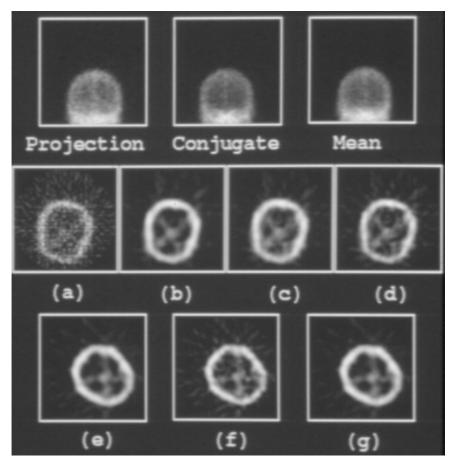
34 show a set of opposing projection images as well as their geometric mean for two patients. Transverse SPECT images were reconstructed after performing geometric averaging of conjugate projections and (prereconstruction) restoration using the Wiener, PSE, and Metz filters [86]. Figures 10.33 and 10.34 show one representative SPECT image in each case, along with several restored versions. The results show that averaging of conjugate projections improves the quality of the restored images, which are sharper than the images restored without averaging.
